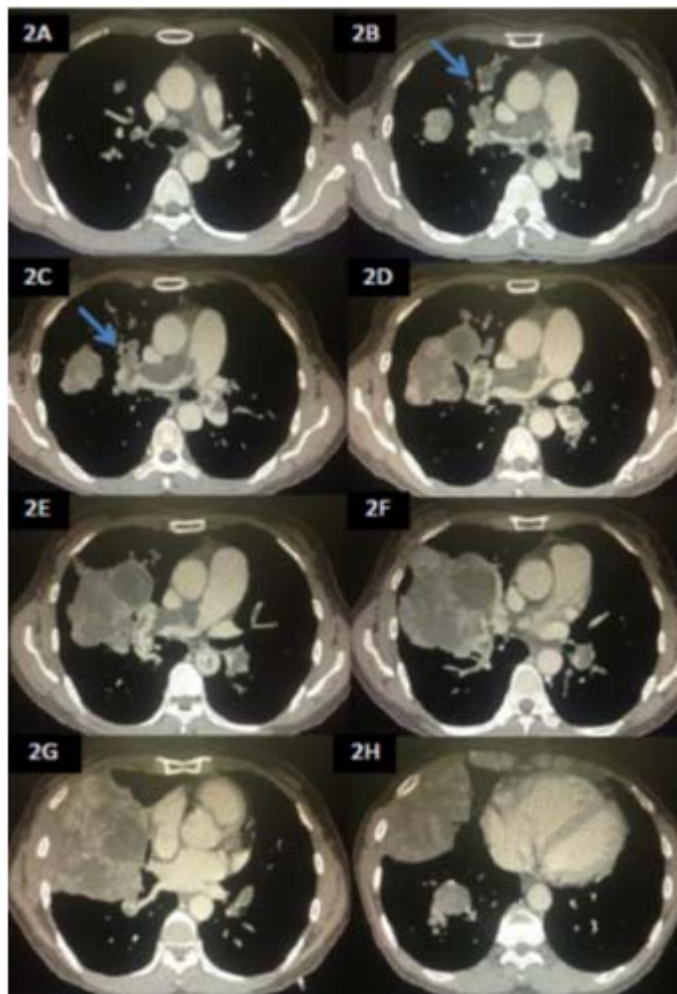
(2A)Chest CT shows intraluminal filling defect in the pulmonary trunk; (2B-C) Chest CT shows intraluminal filling defect with enhancement at the proximal part of right and left main pulmonary arteries and multifocal dilatation of vessels with bead-like appearance (arrow); (2D-H) Chest CT shows intravascular filling defects and a large lung mass with heterogeneous enhancement at the right middle lobe.
